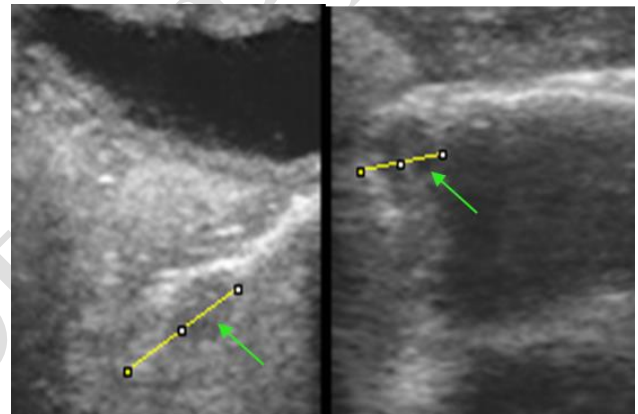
Ultrasound image of the K+ group ovaries. Green arrows indicate the development of follicles, both small and dominant follicles.
